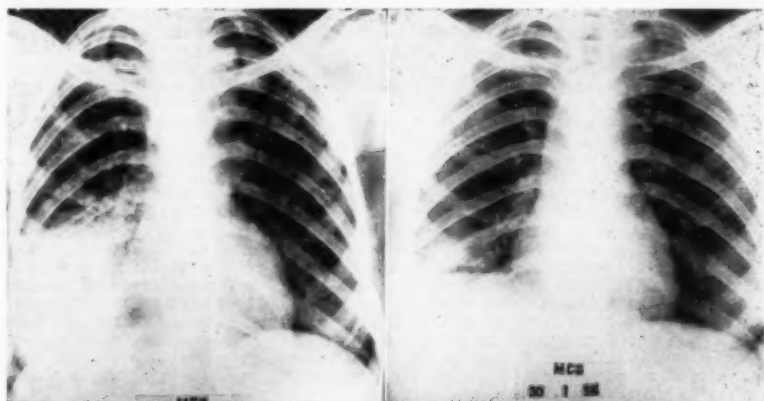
(Case 4) M. C. O., Chest roentgenogram, October 29, 1957 showing extensive bilateral lesions and a great block of condensation at right lower lobes.
